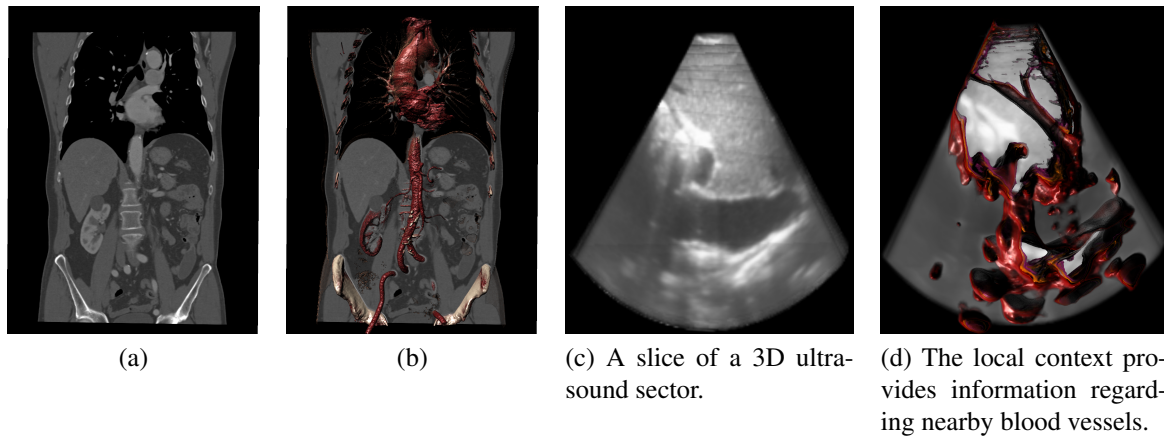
Using the deformed membrane, we can add context to slice rendering for different types of medical data. (a) show slice of a CT dataset. In (b), context is added in form of bones and blood vessels. (c) and (d) show a similar case for 3D ultrasound data
